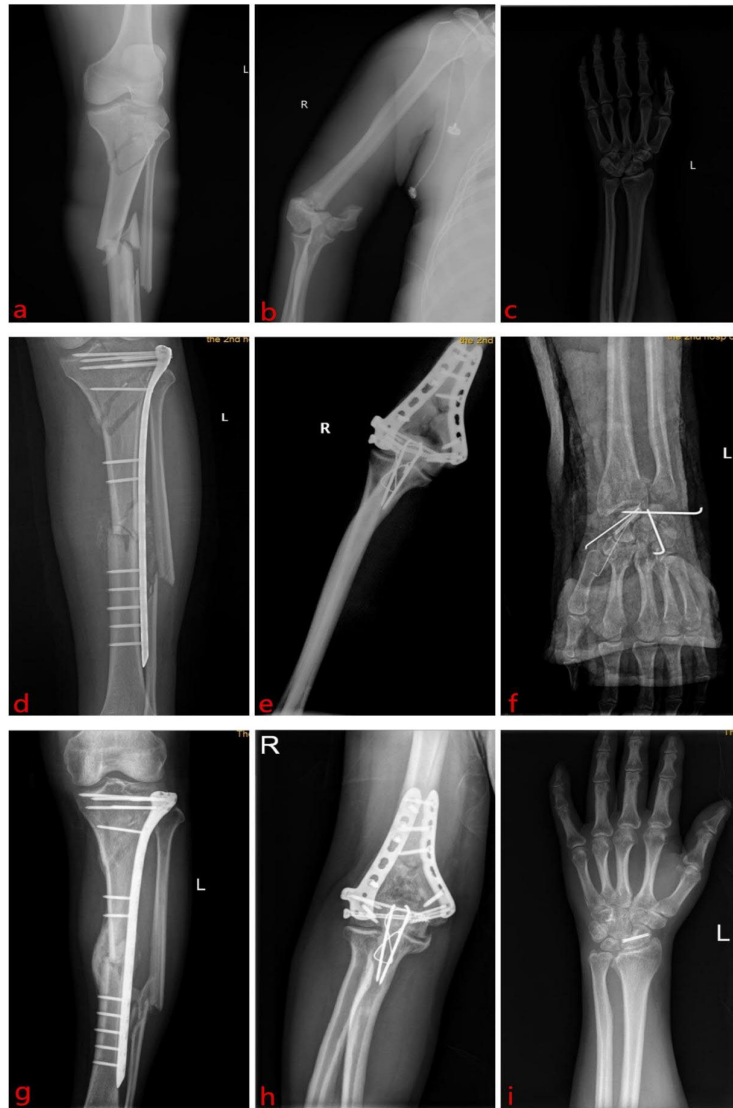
a. X-ray showed: left middle and upper tibial and fibular fractures, involving the tibial plateau; b. X-ray showed: right humerus and ulna comminuted fractures, poor elbow alignment; c. X-ray showed left scaphoid, capitate and hamate tearing fractures; d. Postoperative X-ray showed: metal instrumentation in place with well aligned tibial fracture ends; e. Postoperative X-ray showed: metallic internal fixation in place, fracture ends well aligned, and the elbow relationship returned to normal; f. Postoperative X-ray showed: metal internal fixation in place, the fracture ends well aligned, and the wrist relationship did not show significant abnormalities; g. three months after discharge X-ray showed: the original fracture showed callus formation, metal internal fixation without loosening or displacement; h. three months after discharge X-ray showed: the original fracture healed well, normal joint relationship, metal internal fixation without loosening or displacement; i. three months after discharge X-ray showed: left carpal fracture recovered well, joint relationship with no abnormalities, retain scaphoid internal fixation, the remaining hardware removed.
